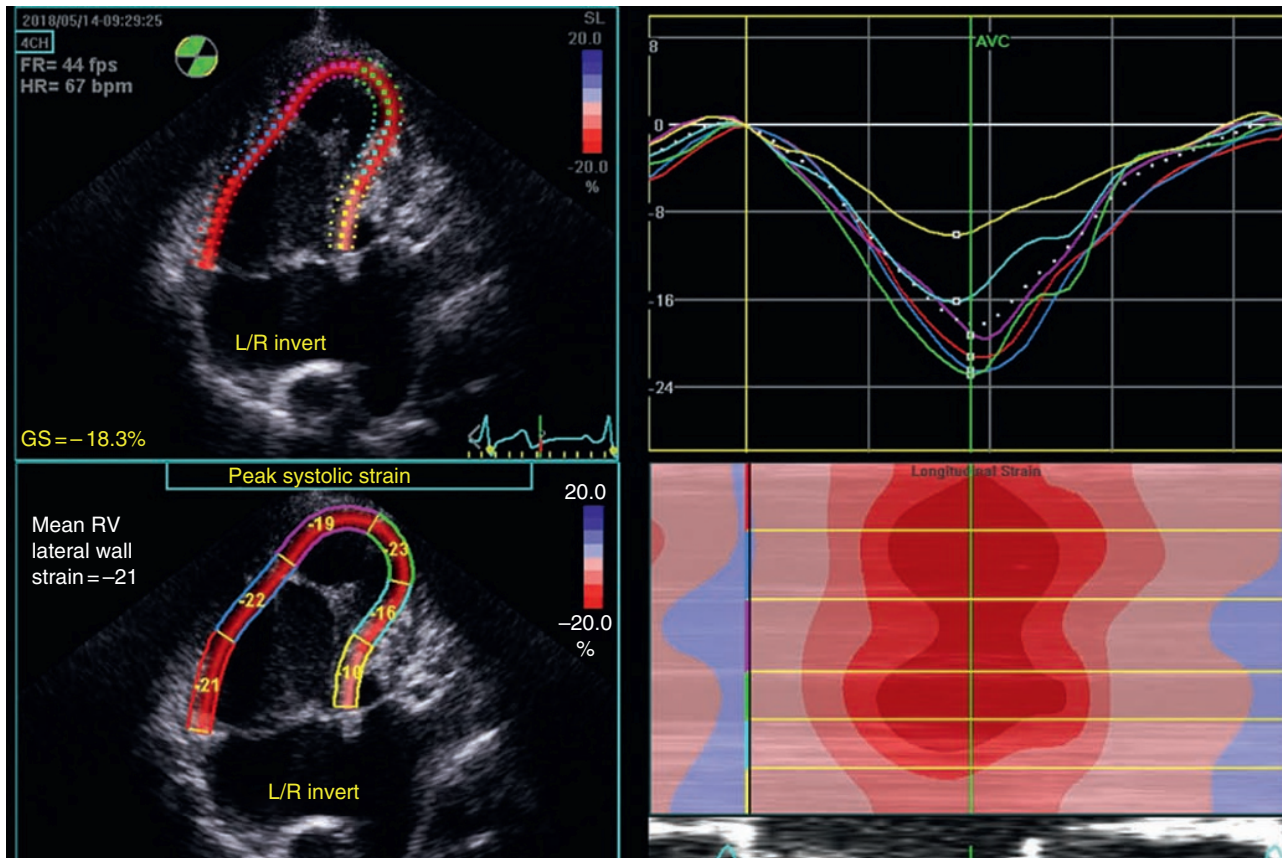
Strain measurements in the single right ventricle using speckle-tracking echocardiography. From an apical four-chamber view, longitudinal strain can be estimated. The mean RV lateral wall strain values are around -21% , within normal range for a systemic RV.
